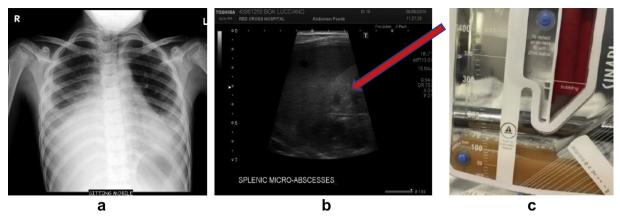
a: Chest radiograph at presentation, shows right pleural effusion and bilateral parenchymal infiltrate. 2b: Abdominal ultrasound shows multiple splenic abscesses. 2c) Intercostal drain collection shows the chylous tuberculous effusion.
